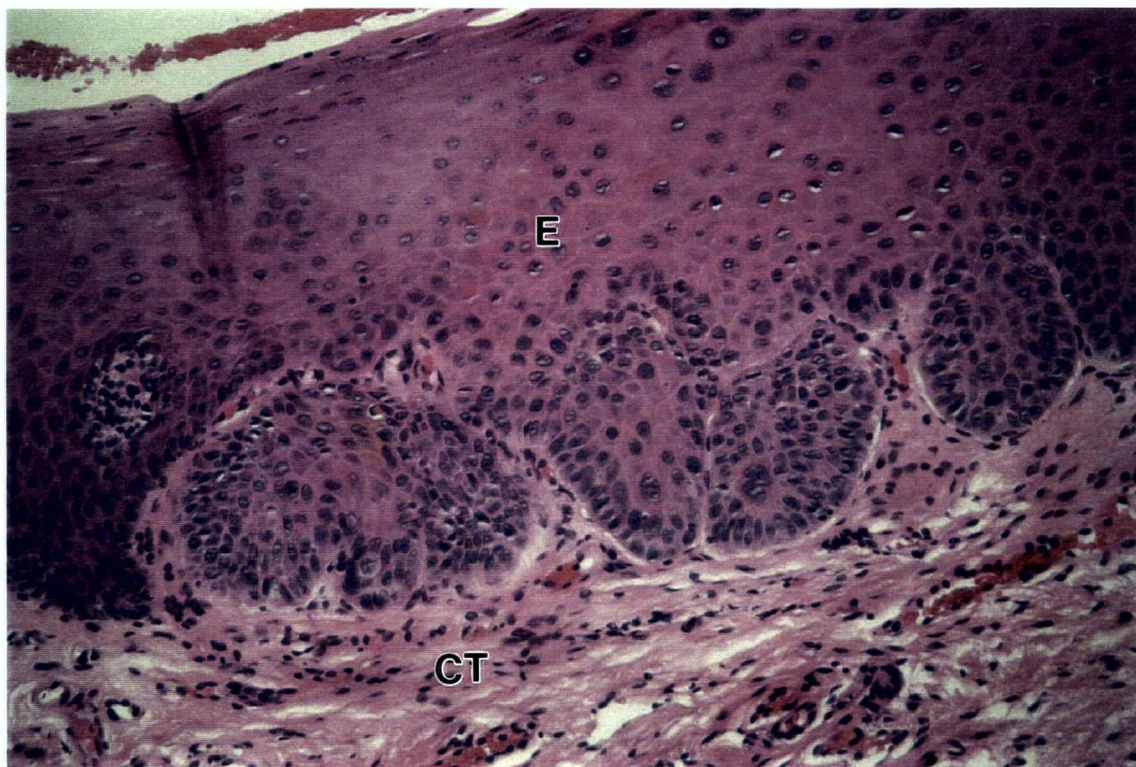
Severe dysplasia; E=Epithelium, CT=Connective tissue
